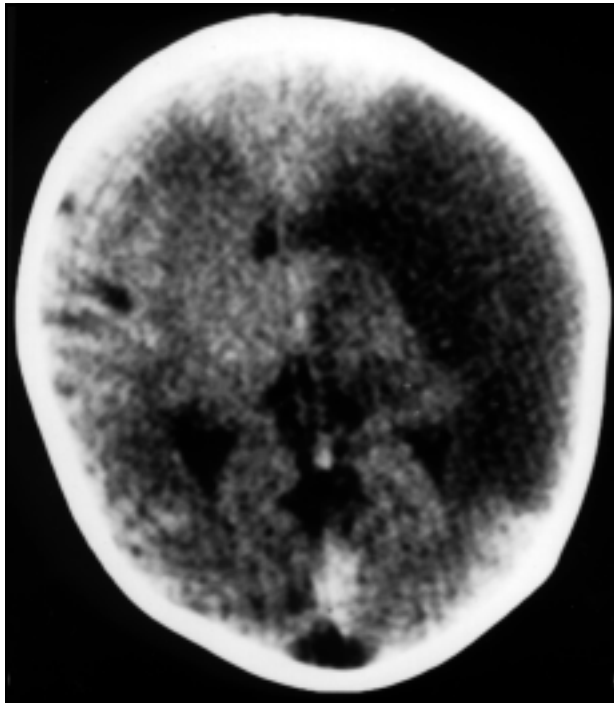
CT. Patient 1 - Left middle cerebral artery territory involved.
